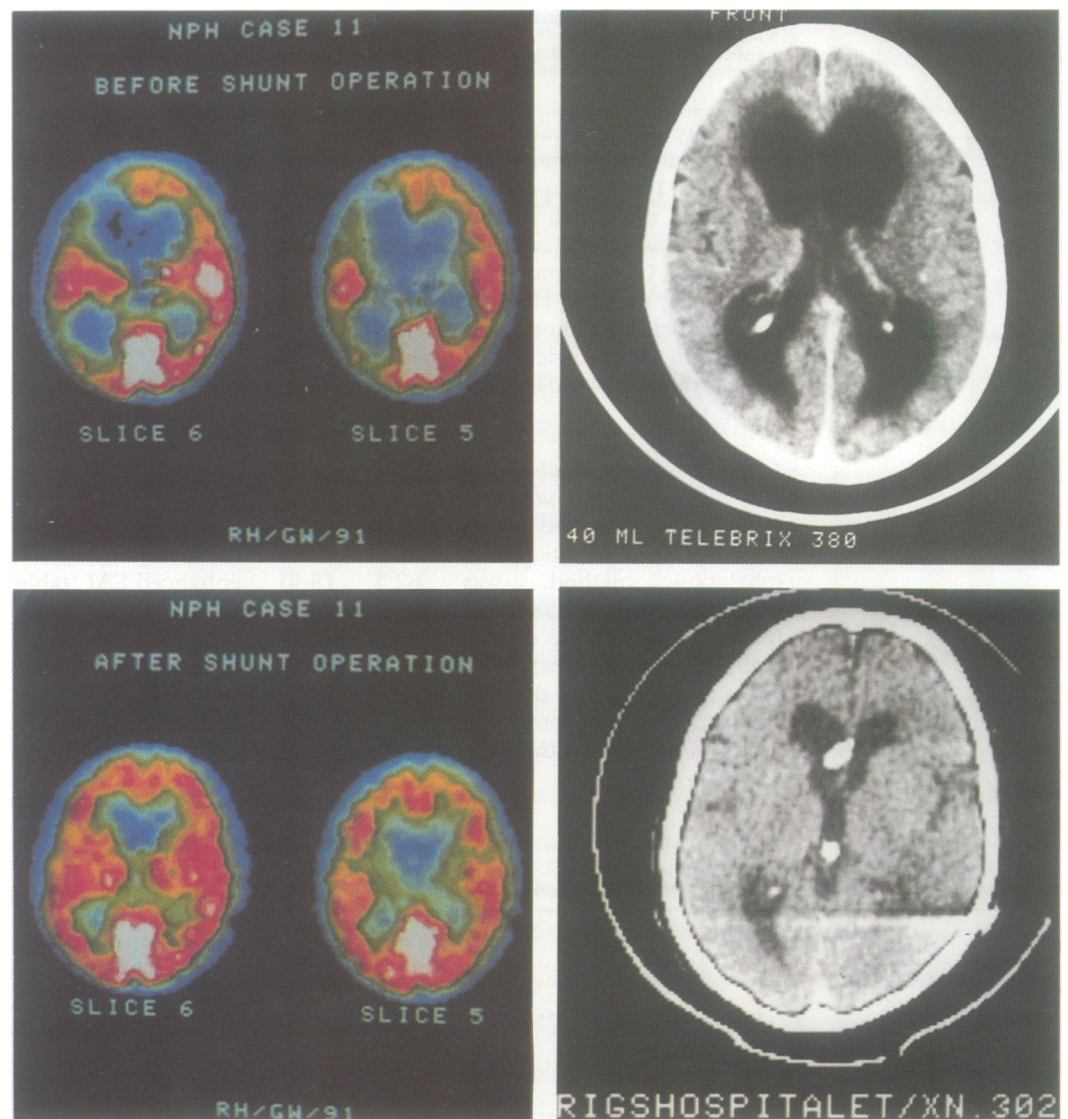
SPECT with [^{99m}Tc]-d,l-HMPAO (left) and CT (right) of the brain in a 72 year old female patient (case 11) with NPH of unknown aetiology before (top) and 3 months after (bottom) shunt operation. The left hemisphere is shown to the left. The colour scale for the SPECT images is shown in fig. 2. However, for the top SPECT image obtained before shunt operation the scale values were higher (0–160%). This patient had a severely enlarged subcortical low flow region. The mean rCBF in the surrounding cortical rim was elevated, despite severe focal flow deficits, particularly in the left frontal and temporal lobes. After shunt operation (with a good clinical outcome), cortical rCBF was normalised, and the area of the subcortical low flow region was markedly reduced, although not normalised.
